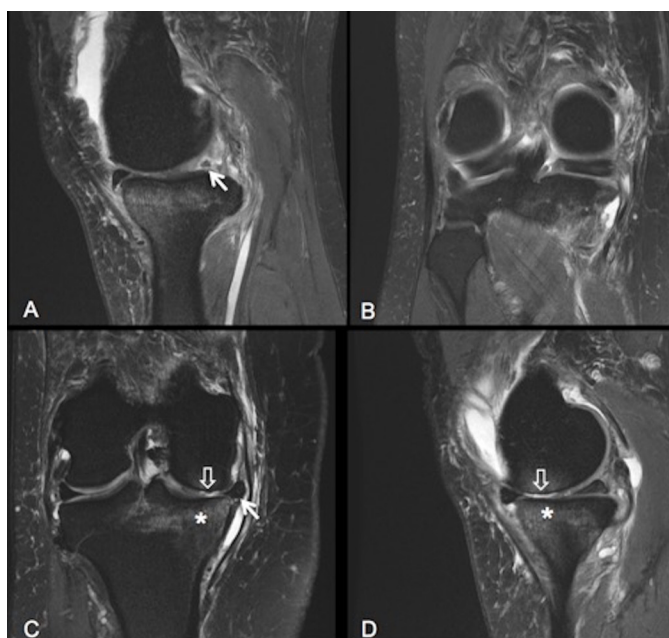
Sagittal (A) and coronal (B) fast spin echo (FSE) T2-weighted fat suppression images show the oblique tear of the posterior horn of the medial meniscus extending into the root attachment (white arrow). Coronal (C) and sagittal (D) FSE T2-weighted fat suppression images show the peripheral meniscal extrusion at the medial joint line (arrow), grade IV chondromalacia (block arrow) and subchondral marrow oedema (asterisk).
